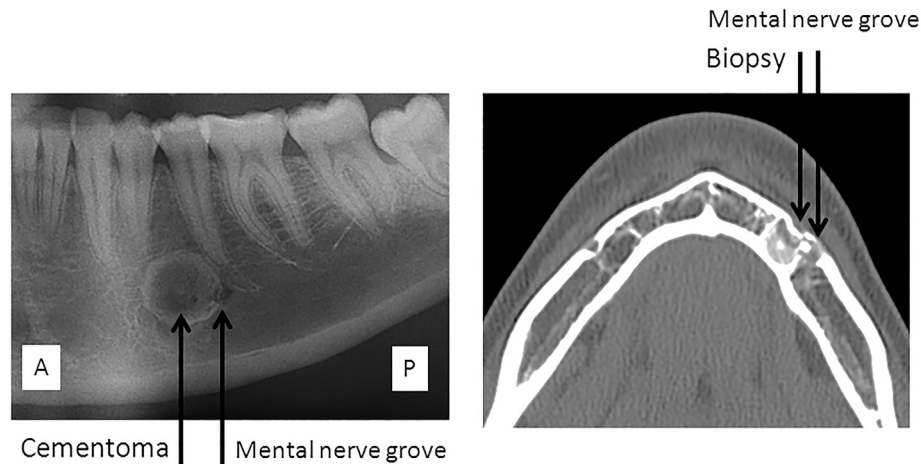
Images of the cementoma and the biopsy-related lesion. The image in the left is an orthopantomography showing the cementoma before biopsy. A: Anterior; P: Posterior. The image on the right side of the figure is an axial TC showing the relationship between the biopsy lesion and the mental nerve groove.
